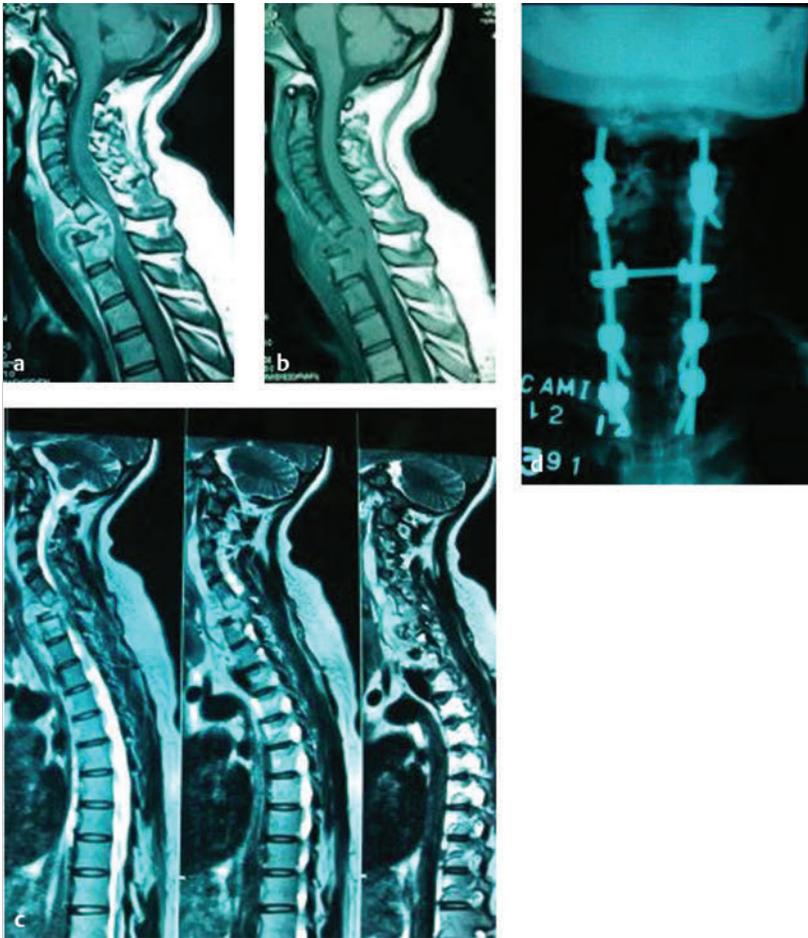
(a–d) Cervical spine tuberculosis. Twenty-four-year-old male with neck pain, moderate quadriplegia, and loss of sphincter function. Contrast-enhanced sagittal MRI T1 sequences reveal destruction of C7 vertebral body with loss of vertebral height, retropulsion of inflammatory mass, cord compression, and kyphotic angulation. Surgical correction with vertebrectomy and multiple level posterior fusion. (Case kindly provided by Dr. José Efraín García Reyes, Hospital Nacional Guillermo Almendra Irigoyen-Lima, Peru.)
